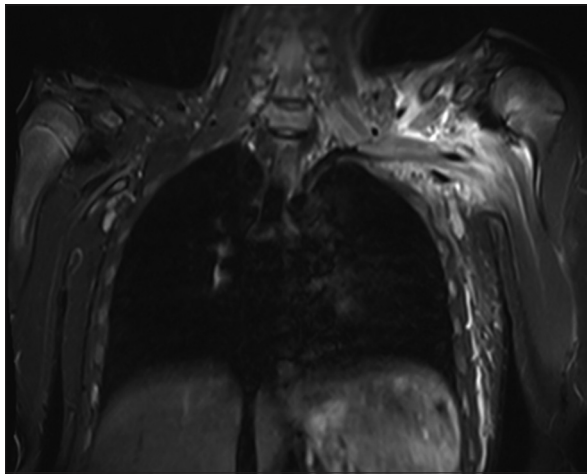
Magnetic resonance imaging - Coronal image
